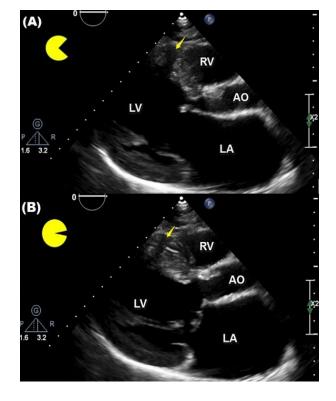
Partial VSD: A) Two-dimensional transthoracic echocardiography (TTE-Parasternal Long Axis View) revealed partial ventricular septal defect (VSD) with a maximal opening like a mouth during diastole (yellow arrow). B) Closed partial VSD during systole (yellow arrow).
